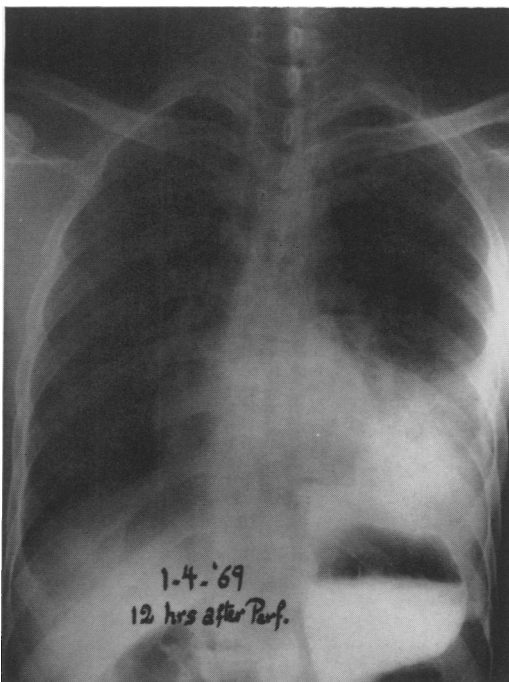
Plain P-A x-ray taken 12 hours after esophageal perforation shows a large collection of fluid in the left chest with mediastinal emphysema.
